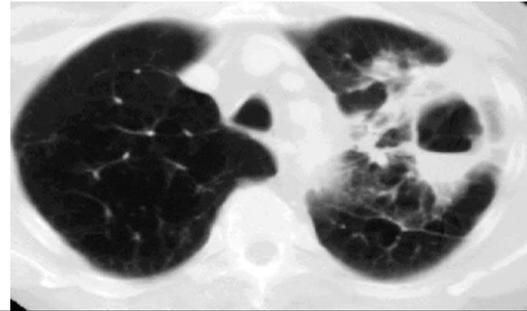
High-resolution CT scan showing the typical apical cavitation in the same patients.
